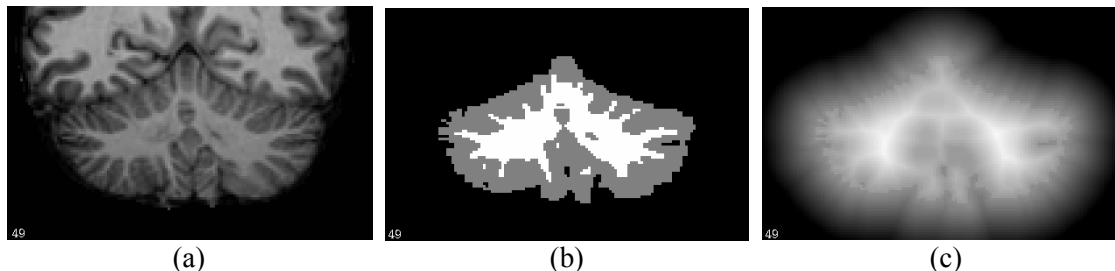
From MR image to level set shape representation. (a) MR image (coronal slice); (b) Cerebellar GM and WM region obtained from FreeSurfer processing; (c) Truncated signed distance function (TSDF) of the whole cerebellum.
